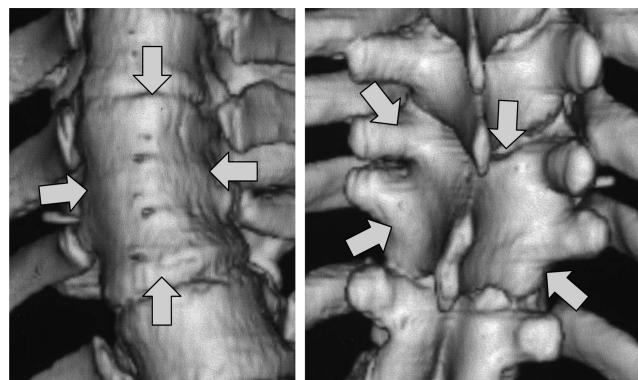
Block vertebra. A 12-year-old girl existing 62° of scoliosis. Front and back images of 3D CT demonstrate no segmentation between T10 and T11 (block vertebra, arrows).
